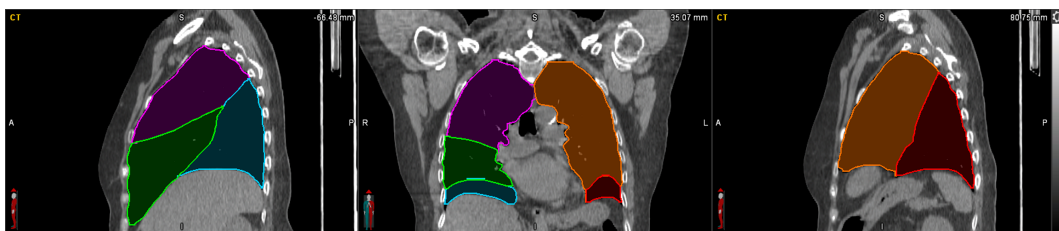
Sagittal, coronal and axial CT slices segmented to show the lobes of the lungs: purple = right upper lobe (RUL), green = right middle lobe (RML), blue = right lower lobe (RLL), orange = left upper lobe (LUL), red = left lower lobe (LLL).
